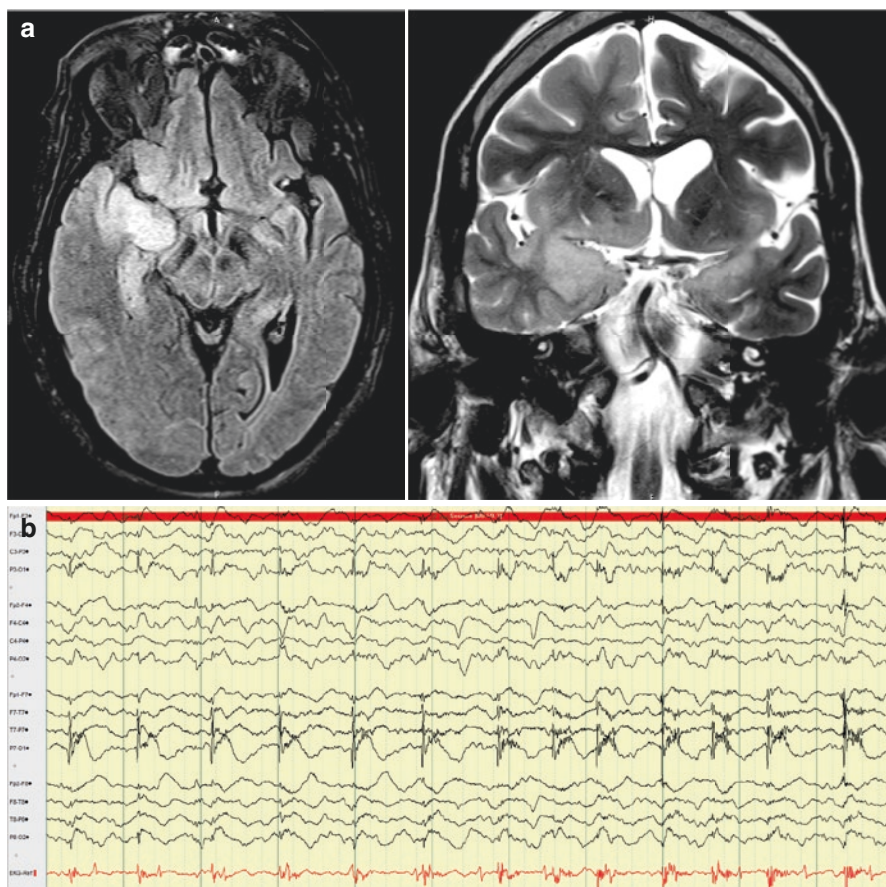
(a) MRI of a 10-year-old male with complex partial seizures and an epidermoid cyst over the left anterior temporal region which was resected 3 years ago. (b) The ictal EEG shows a seizure originating from the left temporal region consisting of a rhythmic theta frequency discharge
